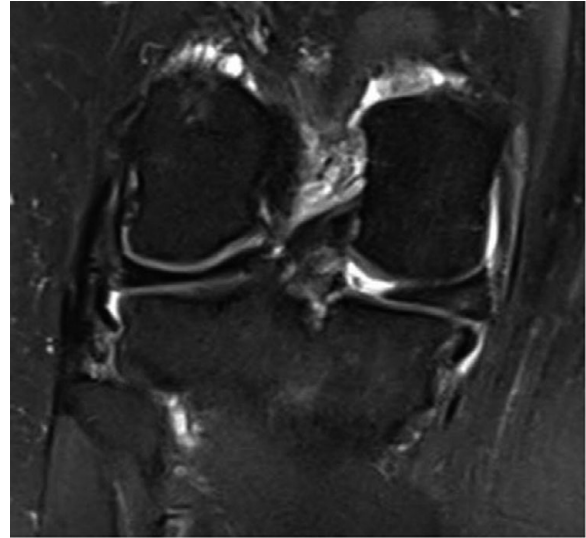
MRI scan knee T2 coronal view
